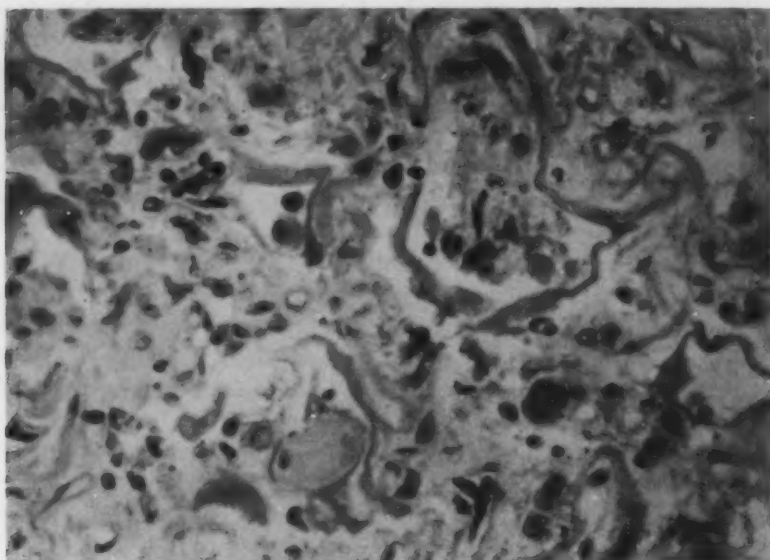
Abnormal alveolar lining cells and early hyaline membrane in human lung that had been irradiated with 200 kilovolt roentgen rays; $\times 266$.
